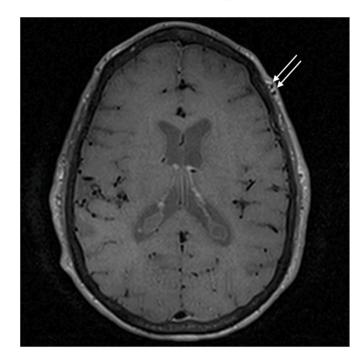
Axial T1-weighted post-contrast image of the head demonstrates enhancement of the left superficial (top arrow) and posterior temporal arteries (bottom arrow). Image obtained one day after presentation. This study was protocoled using delay alternating with nutation for tailored excitation ("DANTE"). The DANTE sequence can highlight enhancement in vessel walls.
